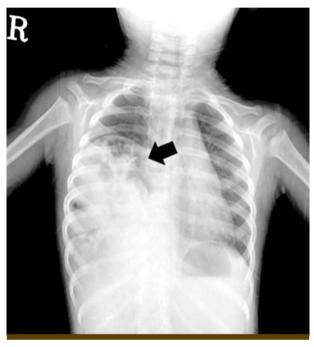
Chest radiograph (posterior-anterior view) showing normal small bowel gas (arrow) with elevation of the right diaphragm.
